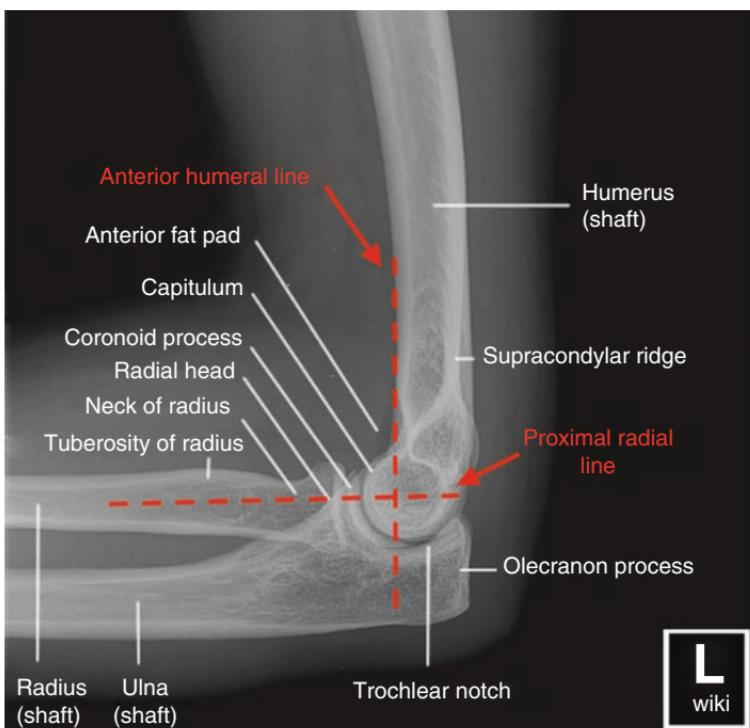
Normal lateral elbow X-ray. (Used with permission from: <http://www.wikiradiography.net/page/Lateral+Scapula+Radiography>)
